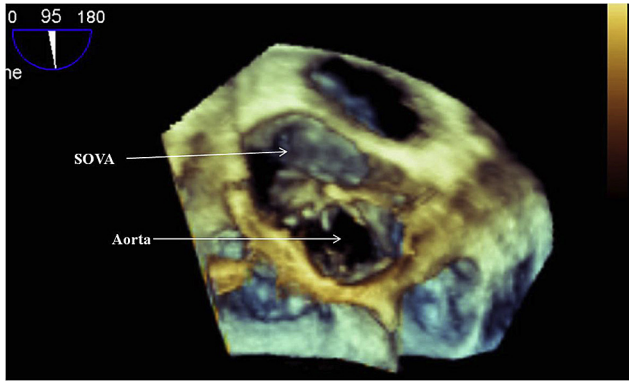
Transesophageal 3D echocardiography showing the unruptured sinus of valsalva aneurysm (SOVA) and aorta (Ao).
